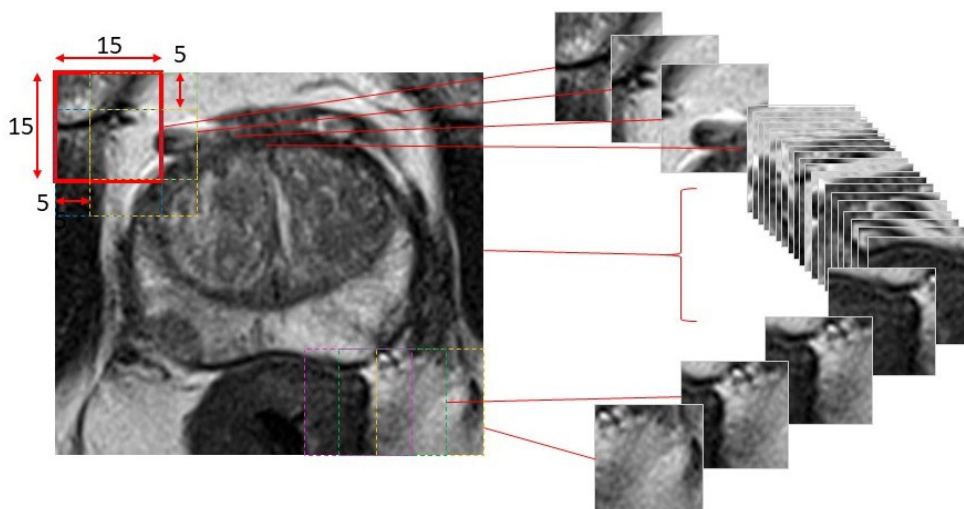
Obtain MRI image patches
